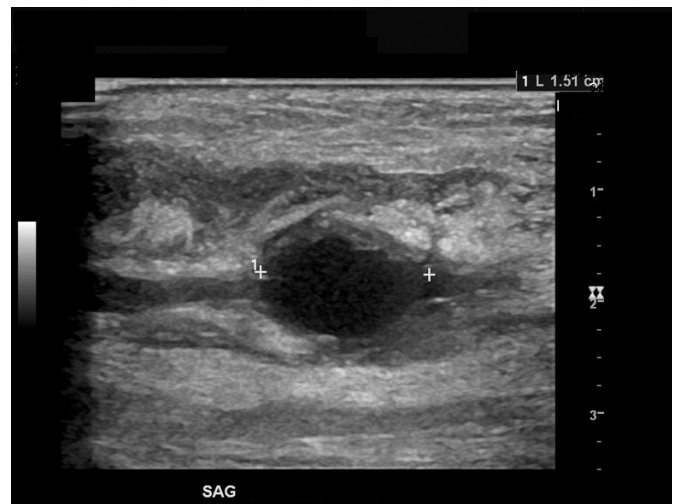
Sagittal plane ultrasound depicting radial artery fusiform aneurysm.
